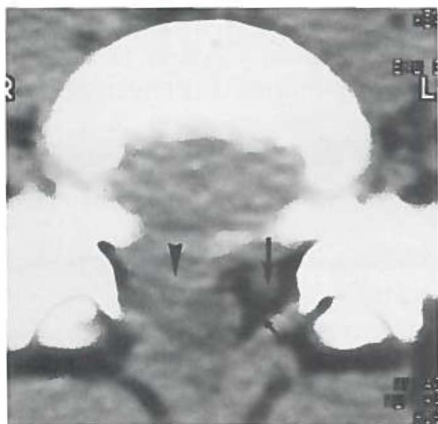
Case 2. CT scan of a right sided posterolateral herniation of disc L5-S1. Note the asymmetrical disc protrusion on the right (arrowhead) with posterior displacement of the right S1 root. The epidural fat is replaced in contrast to normal epidural fat on the left (small arrow) and the sharply defined left S1 root (arrow).
